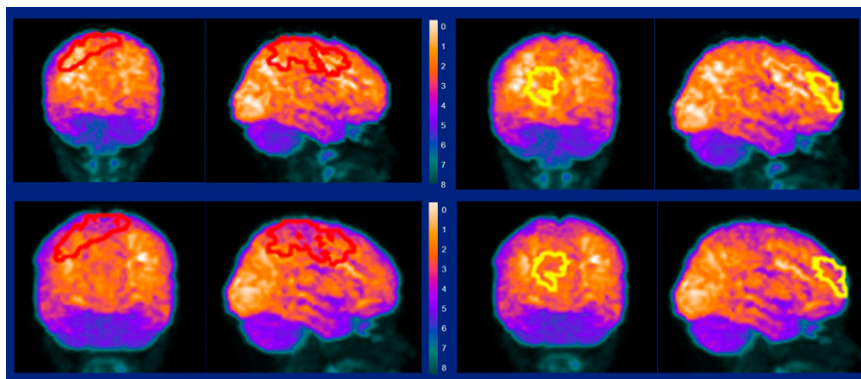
Imaging chemotherapy-induced brain damage in pediatric cancer survivors. Left block: hypermetabolic area in the right frontal lobe (Brodmann areas 8, 9) at baseline (top; SUV_{max} , 12.29) and follow-up (bottom; SUV_{max} , 11). Right block: hypermetabolic area in the right frontal lobe (Brodmann areas 9, 10) at baseline (top; SUV_{max} , 10.9) and follow-up (bottom; SUV_{max} , 9.88).
